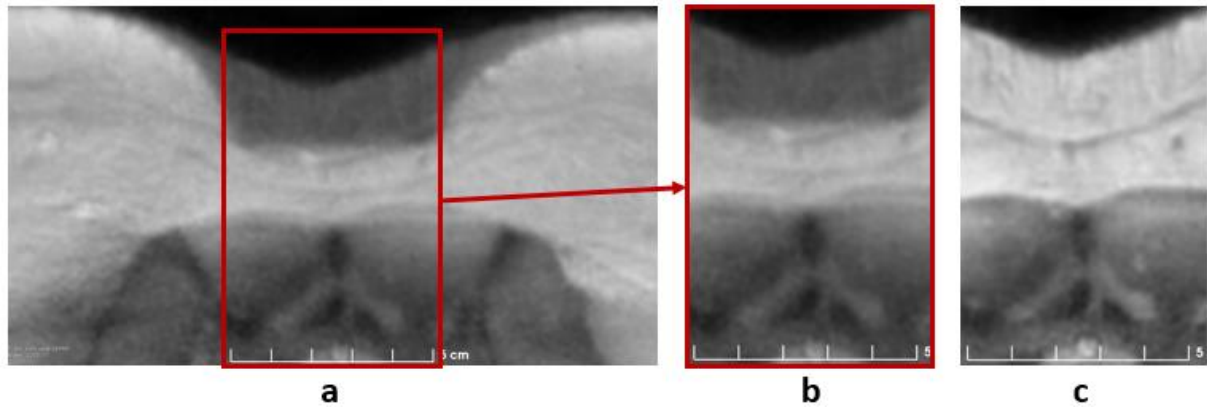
a) Transverse slice of the MR image chosen at the center of indentation mark: overlapping images of L0 (unloaded) and L1 loading configurations b) Selected region of interest: overlapping images of L0 and L1 c) Unloaded configuration L0 only.
